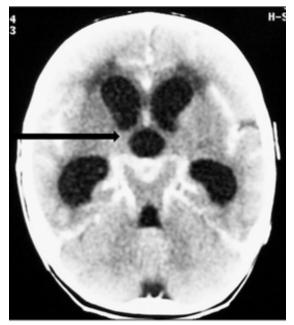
CT scan of the head showing the presence of hydrocephalus
